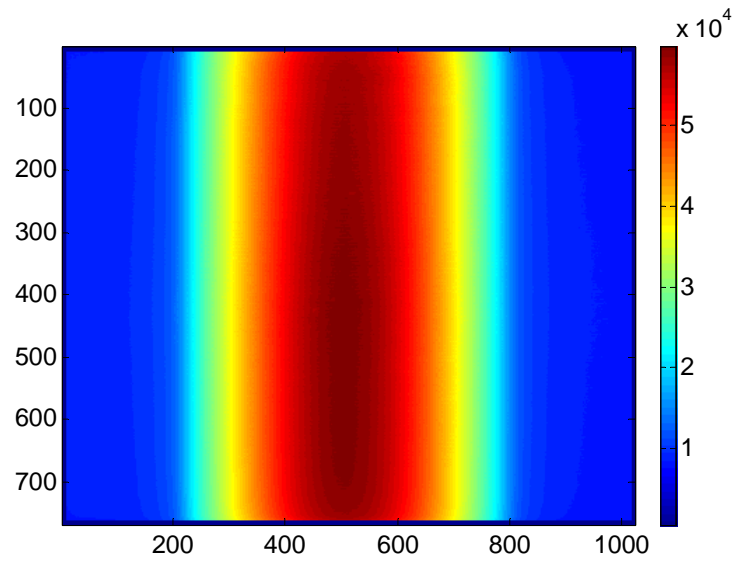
Incident X-ray intensities across the field of view with 80 mA tube current and 10 ms pulse time. Relative intensity is mainly caused by the bow-tie filter.
